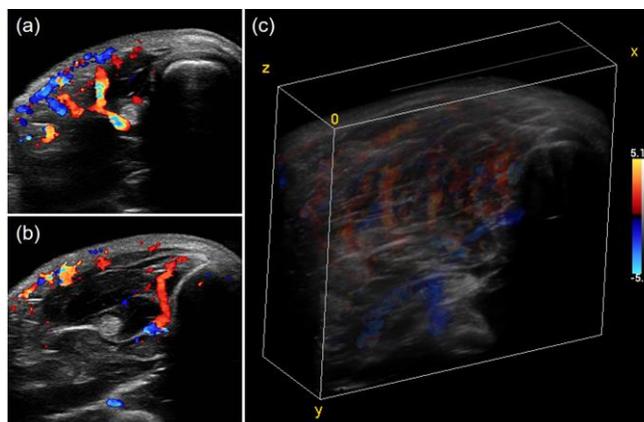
2D and 3D typical ultrasound Doppler images of the greater thenar muscle
